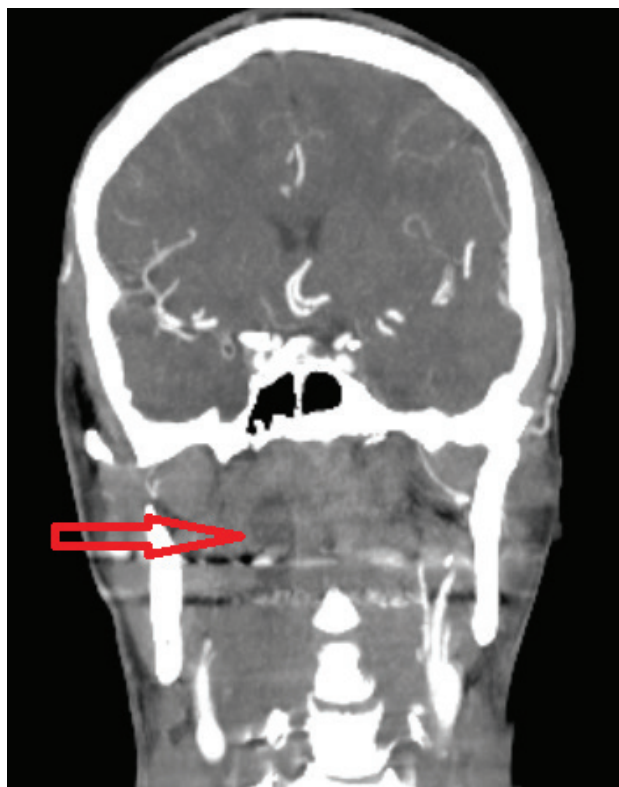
Contrast-enhanced coronal neck computed tomography revealing a right-sided deep neck abscess with parapharyngeal extension (red arrow) and preserved patency of the internal jugular vein.
